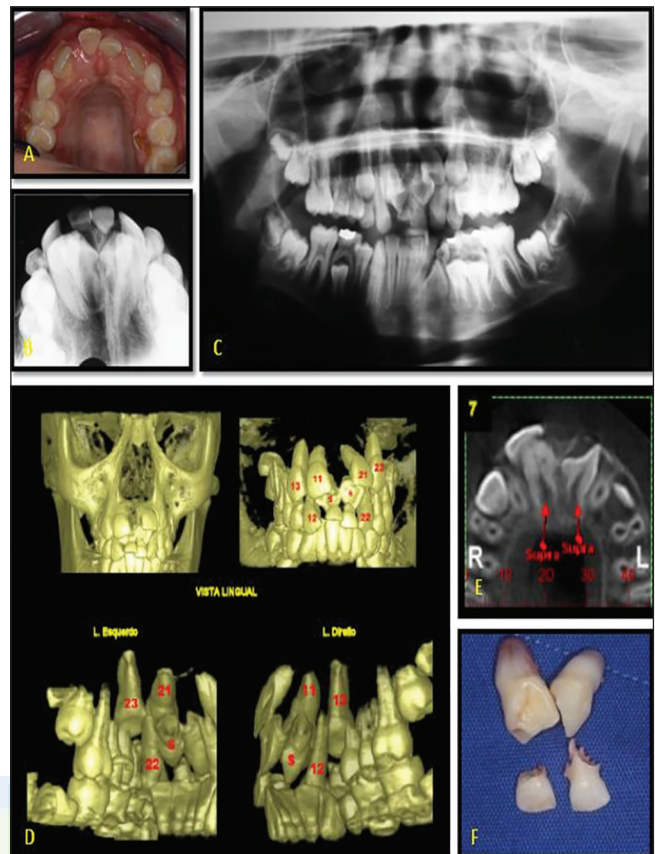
(a) Occlusal view showing teeth 53 and 63 as well as residual root of tooth 52 in the anterior superior region; (b) Occlusal radiograph of the maxilla; (c) Panoramic radiograph demonstrating the presence of supernumerary teeth in the anterior superior region and palatal raphe; (d) The three-dimensional reconstruction for evaluation of impacted teeth 12, 11, 21, 22, and 23; hyperdense image compatible with amorphous dental structure positioned in the region of the alveolar ridge of the right anterior maxilla; (e) Sagittal section; (f) Abnormal supernumerary teeth ($n = 3$) removed.
